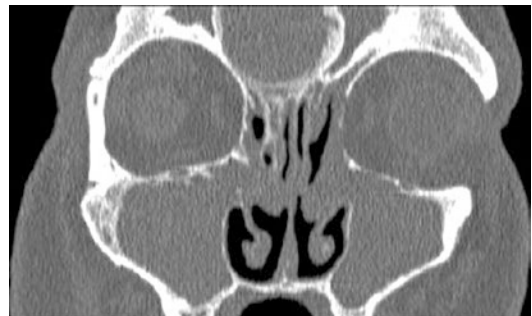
Coronal CT of the paranasal sinuses demonstrating a large mucocele in a Type IV Kuhn cell
